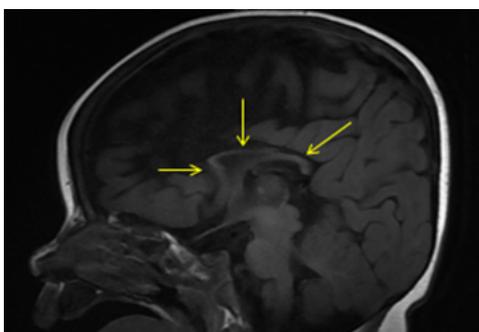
Mid sagittal T1 weighted image on 3T MRI shows diffuse thinning of the corpus callosum (depicted by arrows) in a 2 year old child
